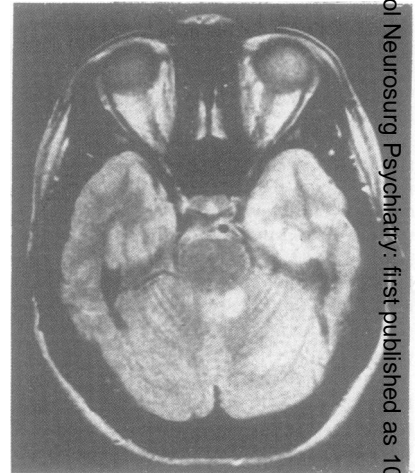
Fig MRI showing high signal from lesion in left cerebellar hemisphere.
